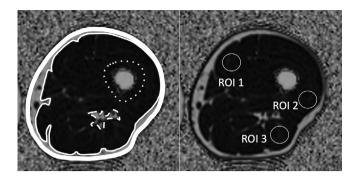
Representative MR imaging for evaluating muscle area, fat area, and fat fraction in the thigh muscle of HD patients. A, Muscle area excluding the subcutaneous fat, the femoral bone, and the neurovascular bundle from the whole area. B, For the measurements of intramuscular fat content, three separate regions of interest are placed in the vastus medialis muscle, the vastus lateralis muscle, and the long head of biceps femoris muscle. MR, magnetic resonance; HD, hemodialysis
